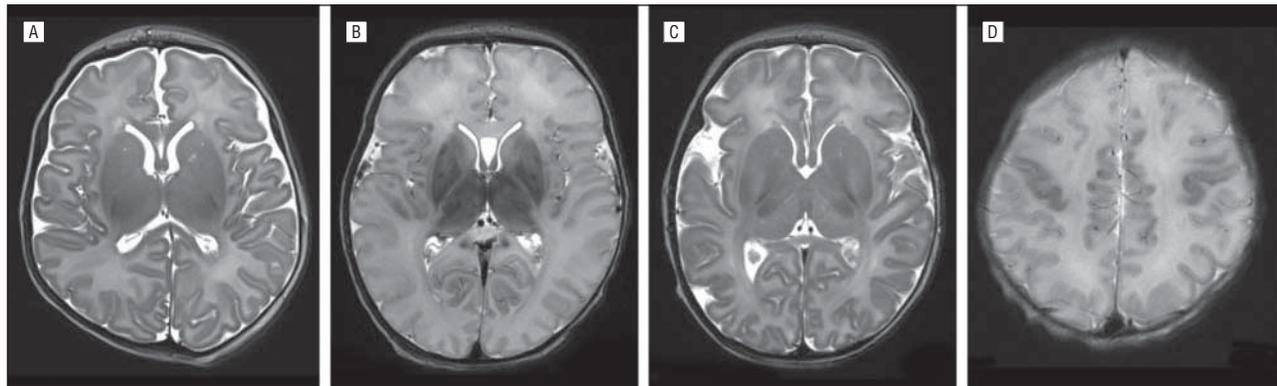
Appearance of hypoxic-ischemic encephalopathy on T2-weighted axial magnetic resonance imaging. A, A normal brain in a term newborn with myelination in the posterior limb of the internal capsule (PLIC). B, Severely abnormal basal ganglia and thalamus (BGT) lesions, absent myelination of the PLIC, and abnormal signal in the white matter, especially in the frontal lobes. C, Moderately abnormal BGT involving the putamen and thalamus, with myelination of the PLIC present. D, Abnormal signal in the Rolandic cortex.
